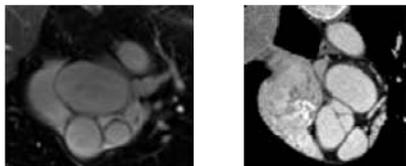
Resampled CT dataset matching orientation & DFOV of MR Data
